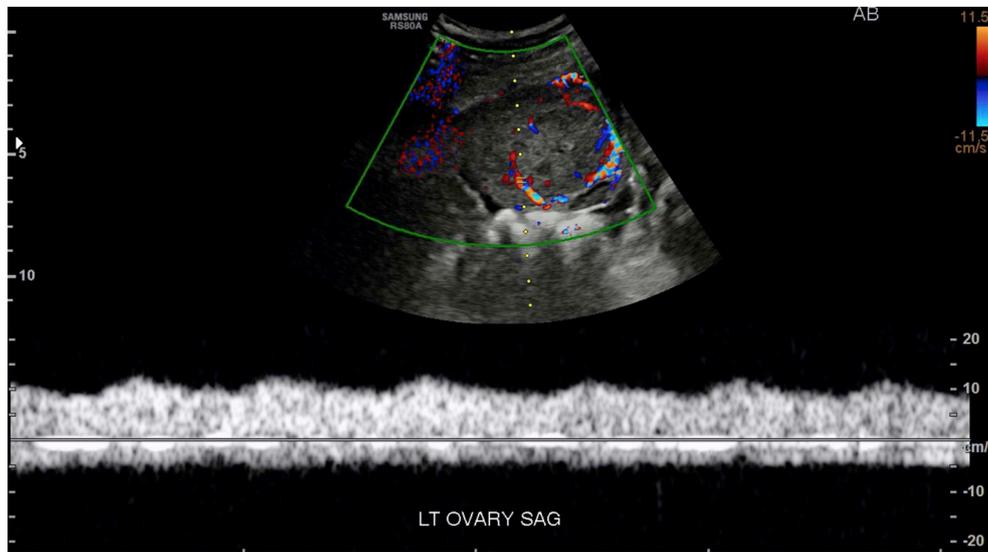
Follow-up pelvic ultrasound with sagittal image of the left ovary demonstrates an interval increase in size and internal vascularity of the predominantly solid isoechoic mass with a low resistance arterial waveform.
